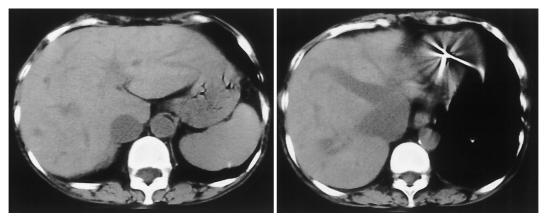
Abdominal computed tomography scans showing findings of congestive liver, but no findings of liver cirrhosis
